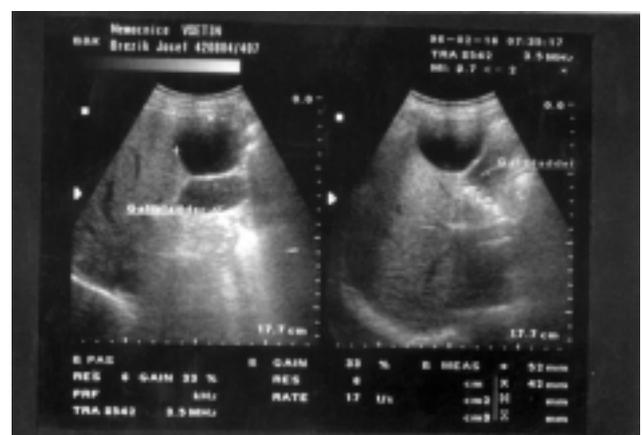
Ultrasonography in a 54-year old man (Liver cyst and cholecystolithiasis)
